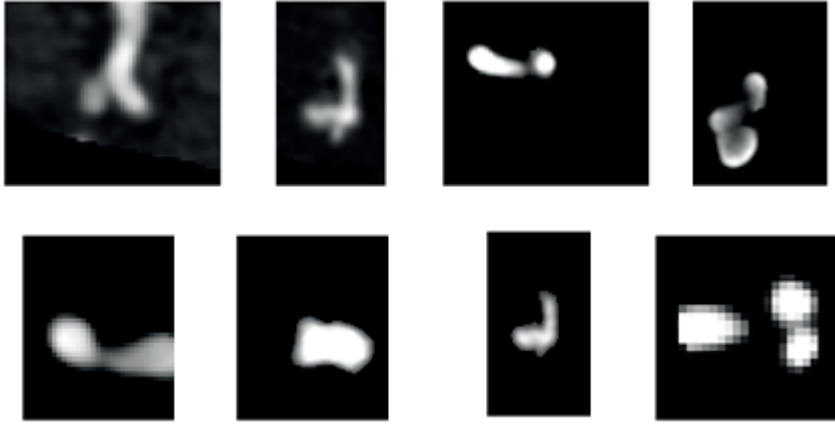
2D CTA or DSA images of the eight cases. Case 1,2,3 and 4 on the top row from left to right and Case 5,6,7 and 8 on the bottom row from left to right.
